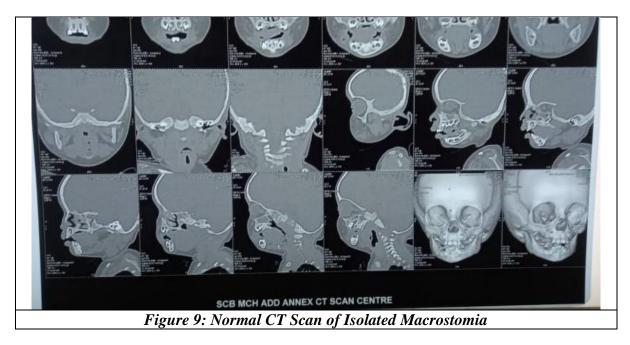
Normal CT scan of isolated bilateral macrostomia
